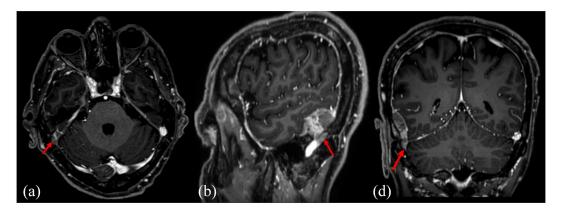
Brain MRI in T1 fat sat after injection of gadolinium showed an invasion of the temporal process in the right sigmoid sinus responsible of the right sigmoid sinus thrombosis (red arrow), in axial (A), sagittal (B) and coronal (D) section.
